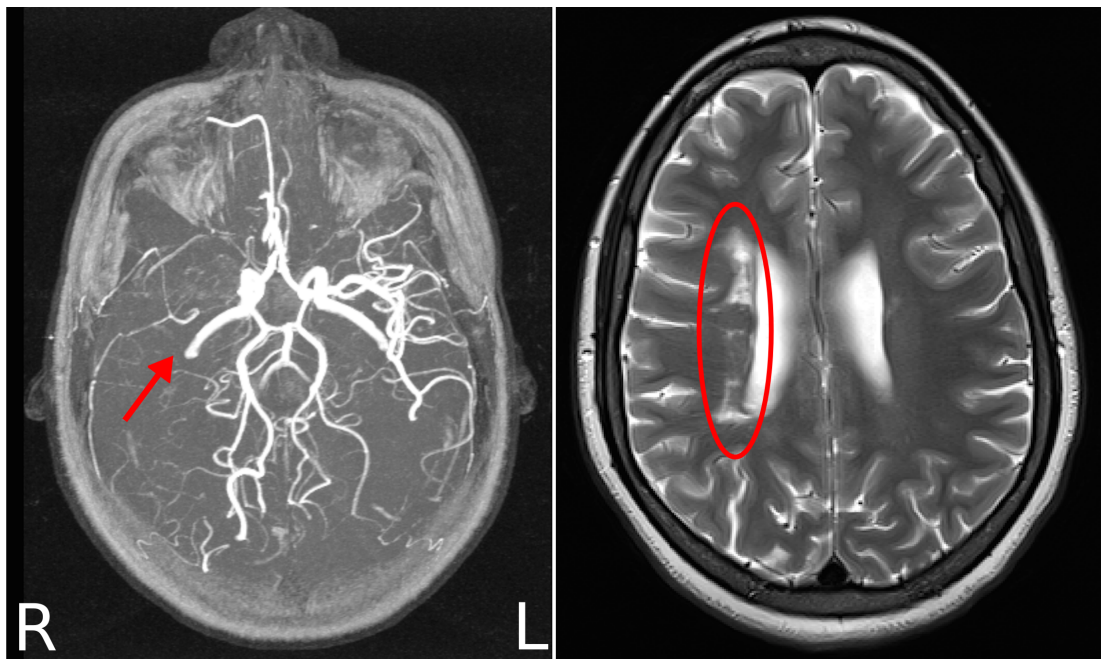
Example of a 19-year-old female with HbSS who experienced a clinical stroke. Left panel shows occlusion of the right middle cerebral artery on MRA, and the right panel shows corresponding hyperintense signal on T2-weighted MRI, indicating area of infarction.
